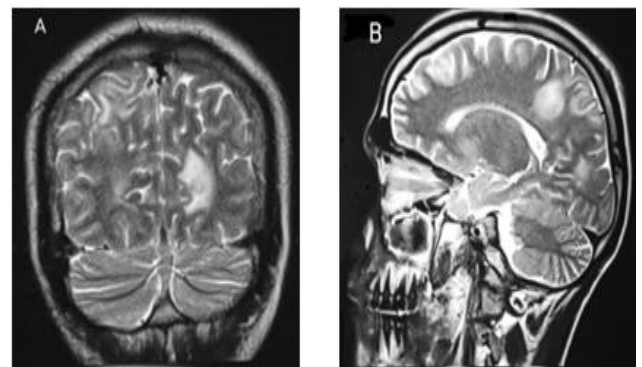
A and B a brain MRI, suggest demyelinating lesions
